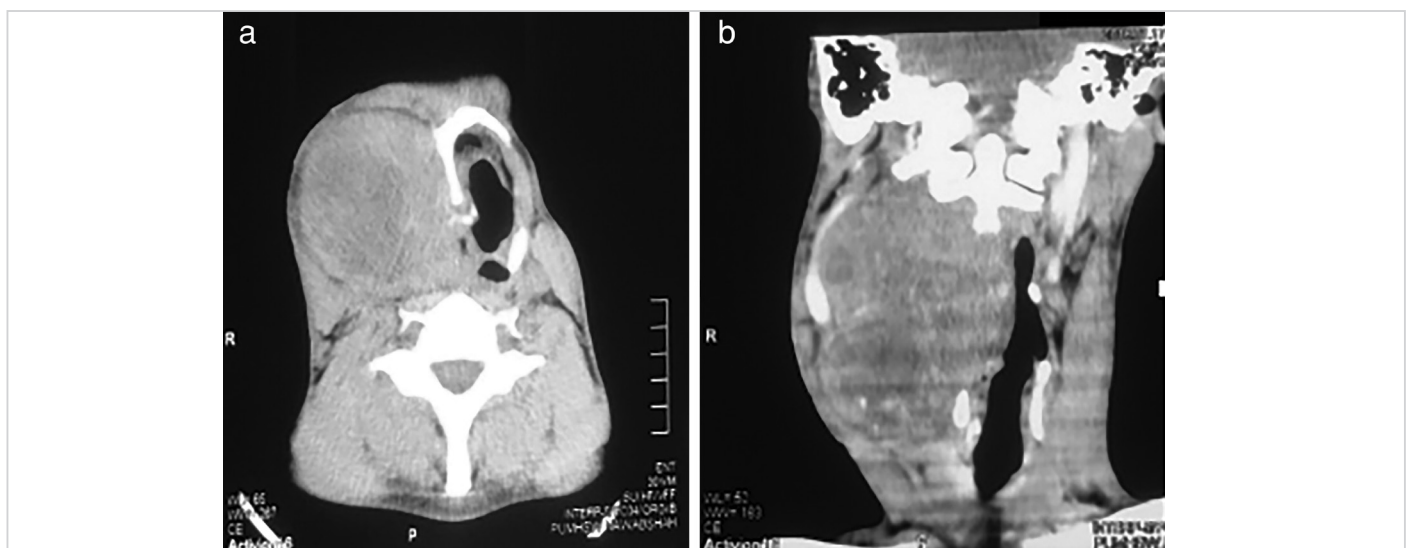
Computed tomography scan showing a large, heterogeneous mass with intact surrounding fat planes. a) Axial image at the level of hyoid bone, b) coronal image
